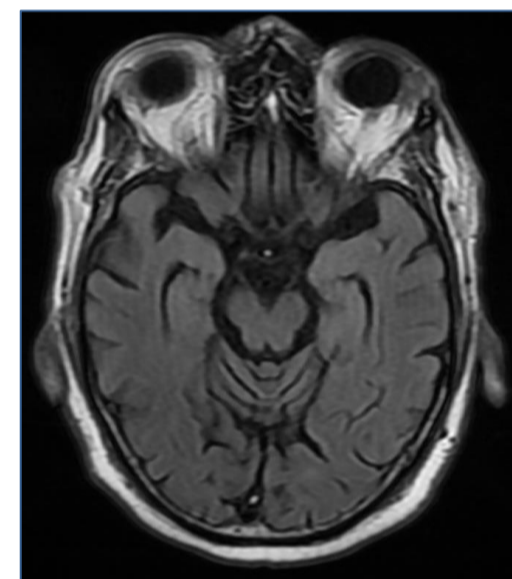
MRI brain without hyperintensity noted around mammillary bodies or midbrain, only noted with less than 20% of patients
